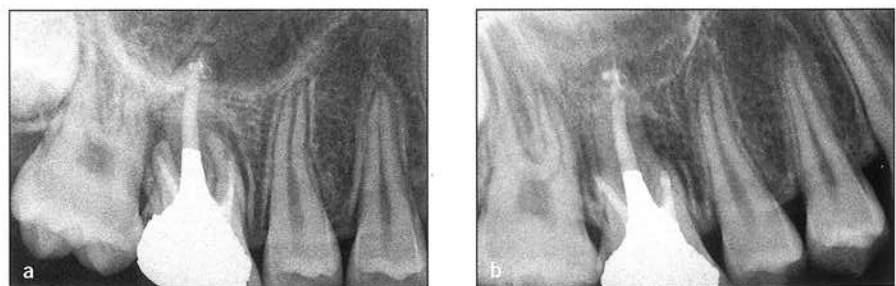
(a) Preoperative radiograph of a maxillary first molar with inadequate root canal treatment in the distobuccal root and ledge formation in the mesiobuccal root. (b) Postoperative radiograph after surgery to correct these inadequacies.
